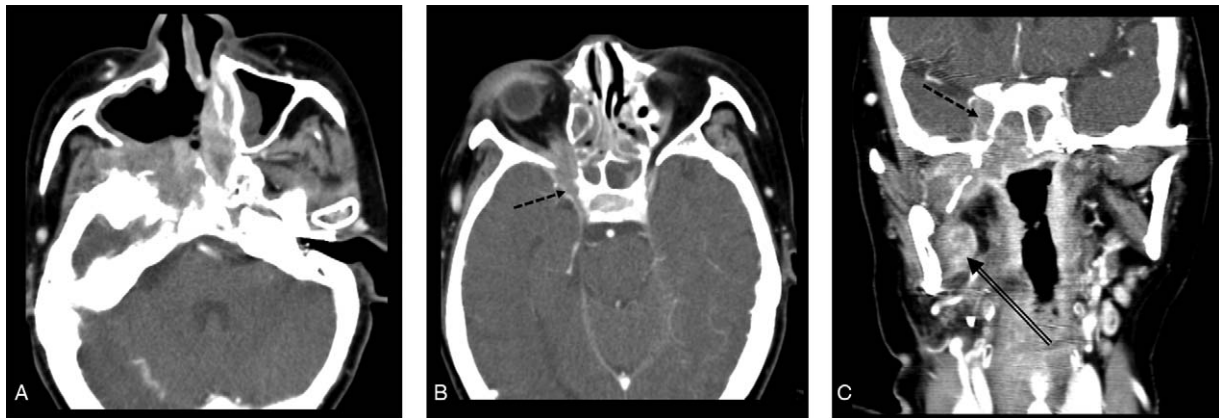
CT images of recurrent lesion. (a) A recurrent lesion destructing the cranial base adjacent to the upper resection margin of the previous surgery. Note the intracranial invasion into the right cavernous sinus through perineural spread (b and c, dotted arrow). Another recurrent lesion in the medial pterygoid muscle (c, double arrow).
